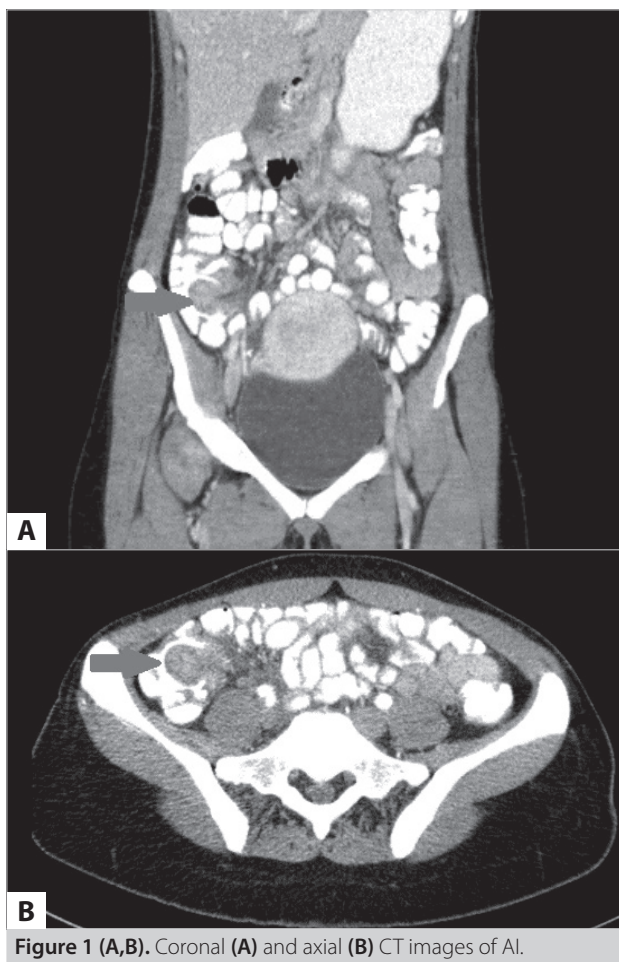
(A,B). Coronal (A) and axial (B) CT images of AI.
